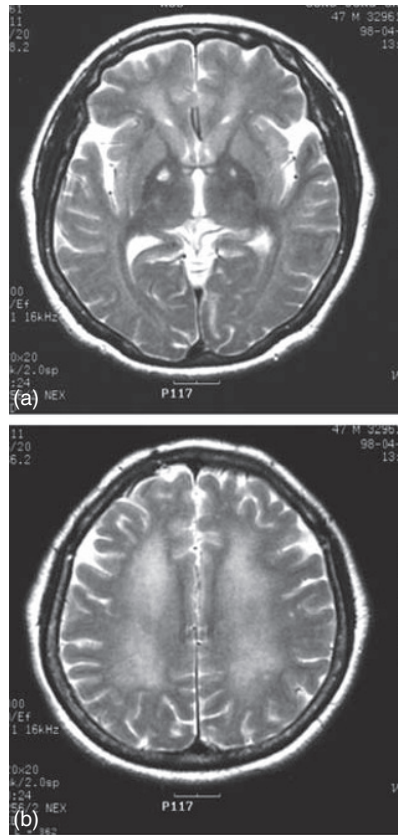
T2-weighted MRI obtained one month after CO poisoning in a patient shows (a) necroses of the bilateral globus pallidus and (b) diffuse high signal lesions in the white matter.
